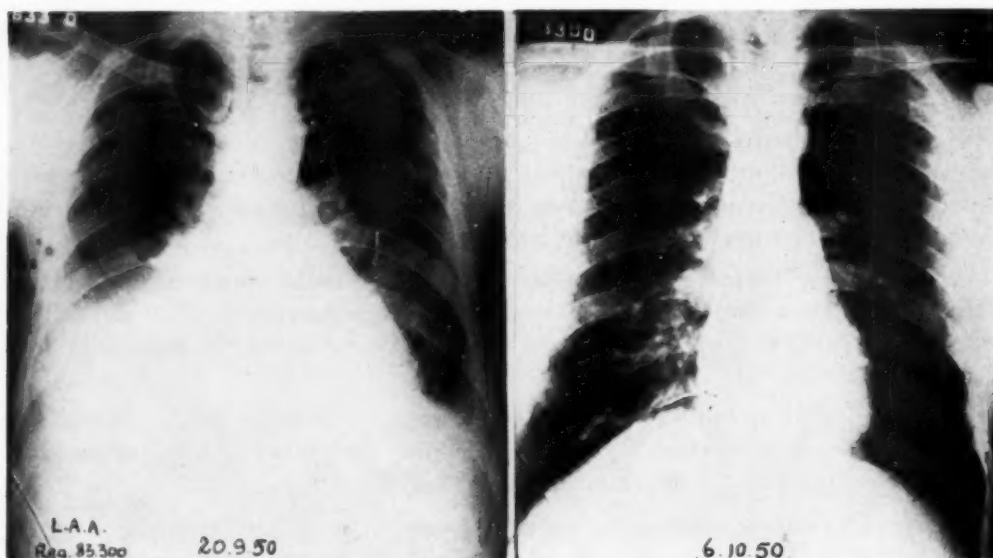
(Case 22).—(L.A.A.)—The initial roentgenogram shows an increased heart shadow with signs of pulmonary congestion and a right-sided pleural effusion. Two weeks later, after thiamine treatment, there is a marked decrease in heart size and disappearance of the pre-existent right hydrothorax.
